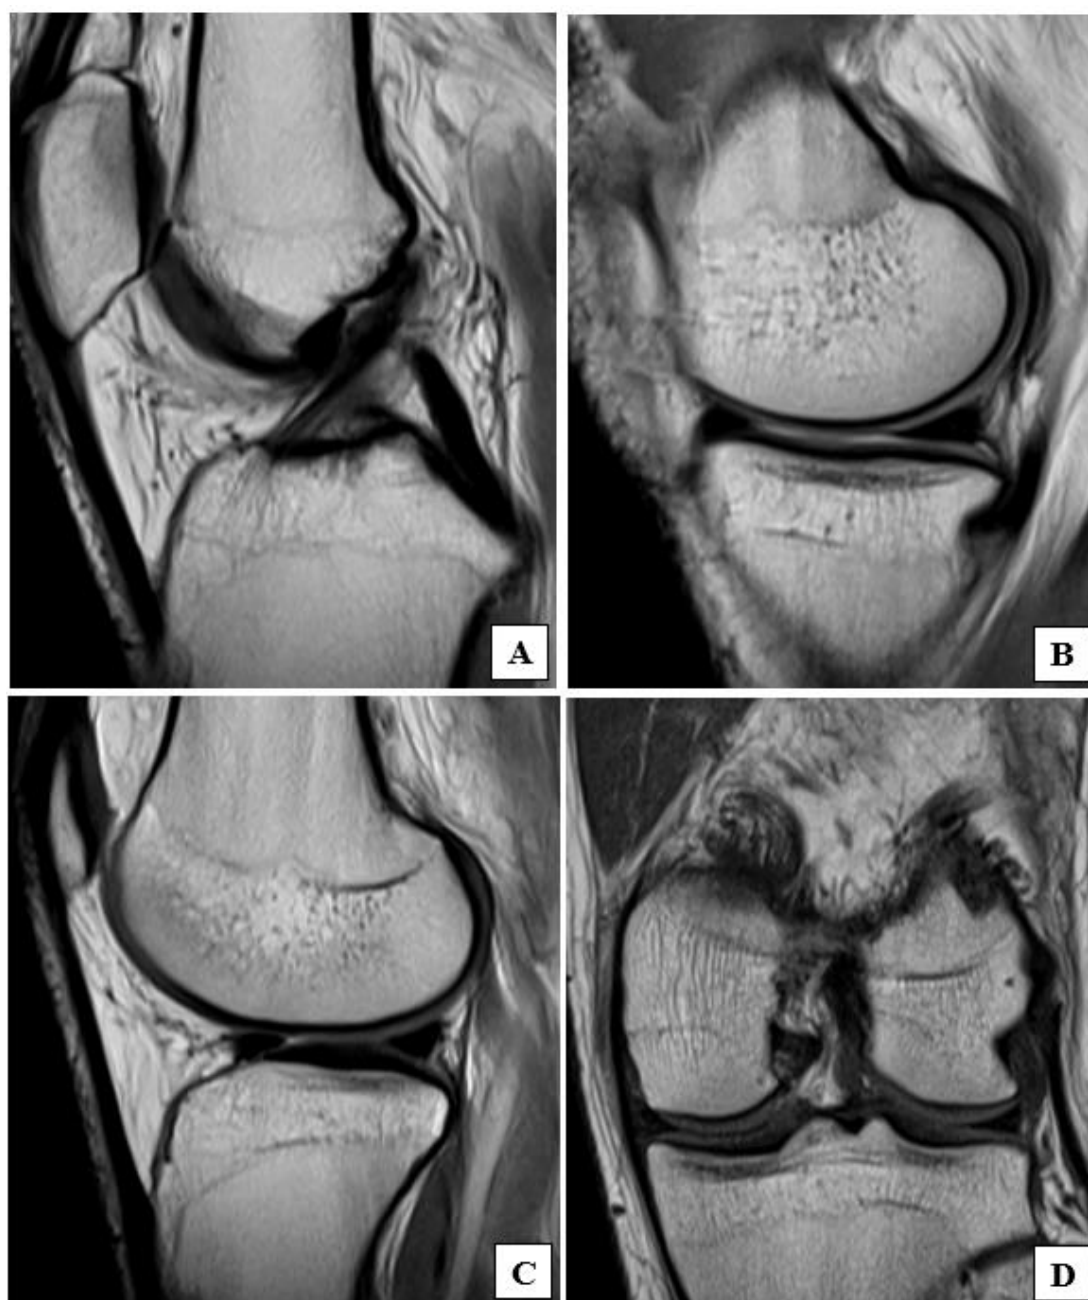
Sagittal (A, B, C) & coronal (D) PDFS MRI images. (A) Normal intensity ACL & PCL. (B) Medial compartment shows the medial meniscus which is wider posteriorly than anteriorly. (C) Image through the lateral compartment shows the normal hypointense anterior and posterior horn of the lateral meniscus. (D) Normal intensity MCL & LCL.
